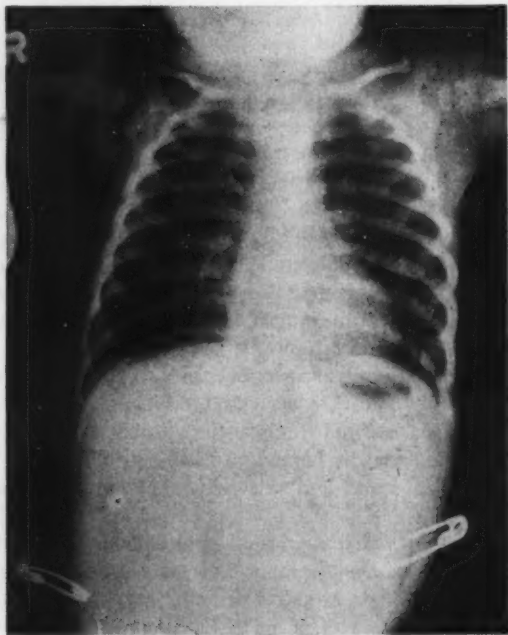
S. K. X-ray of the chest showing flaring at the distal end of the ribs
